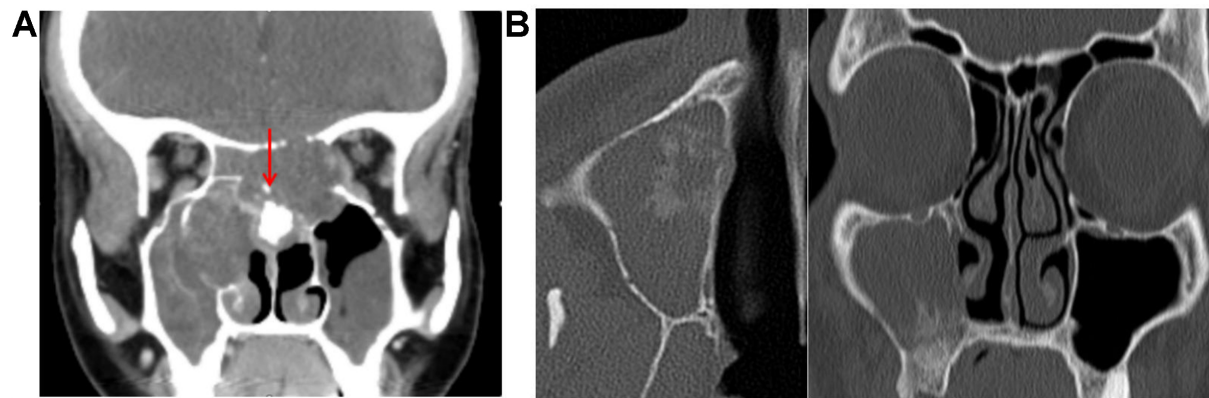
(A) Coronal CT showing the characteristic “ring and arc” appearance of a chondroid matrix in chondrosarcoma; (B) CT demonstrating “sunburst” periostitis and osteoid matrix typical of osteosarcoma. CT: Computed tomography.
